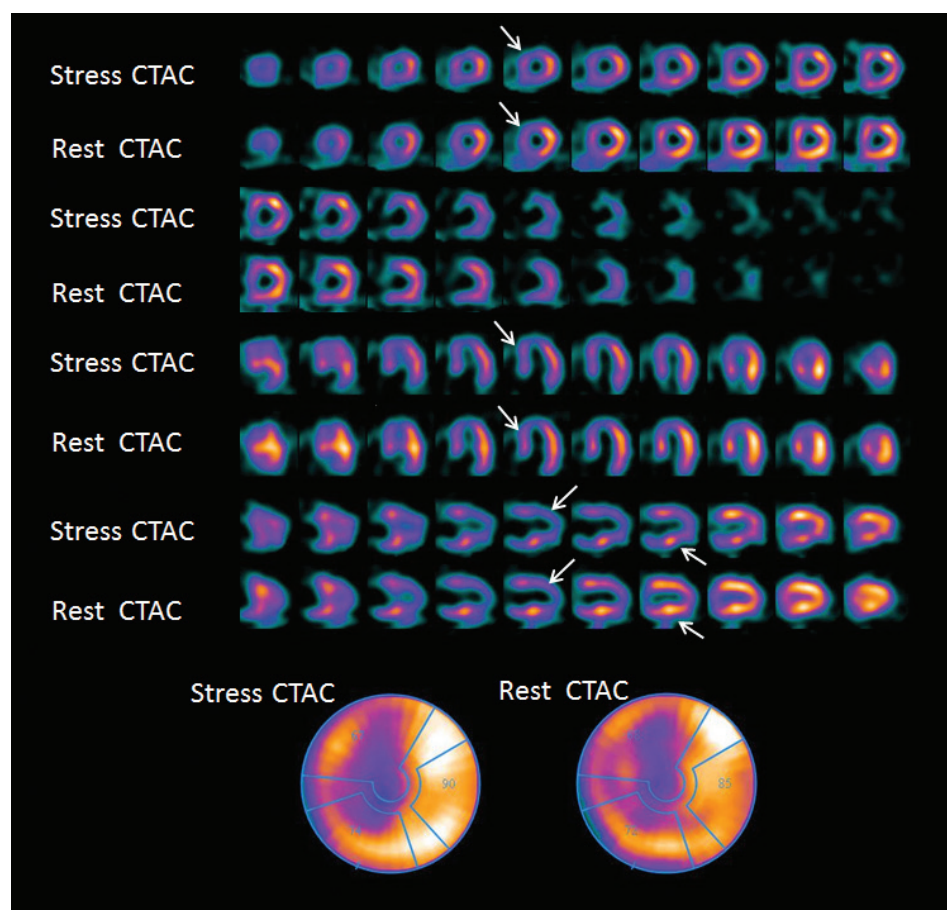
Stress/rest IQ•SPECT myocardial perfusion study shows reversible global ischemia with severe perfusion defects in the anterior and septum walls.
